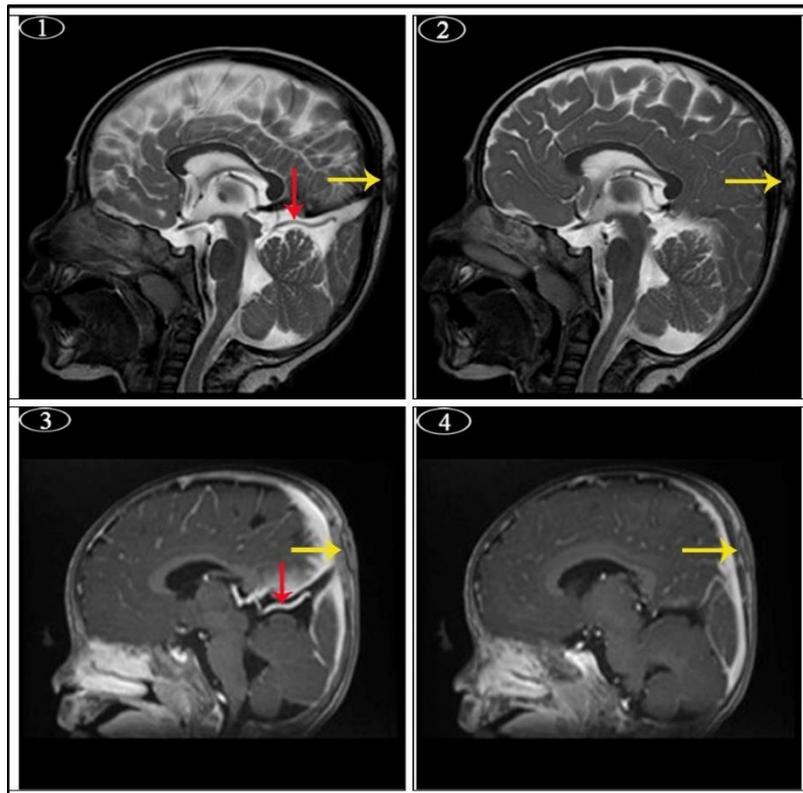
Photos 1 & 2 (T2-MRI), photos 3 & 4 (T1-MRI). All photos are in sagittal plan with post-contrast administration. They show extracranial midline mass with small bony defects (yellow arrows), connected to the dural sinus, and associated with hypoplastic straight sinus and persistent falcine sinus (red arrows).
